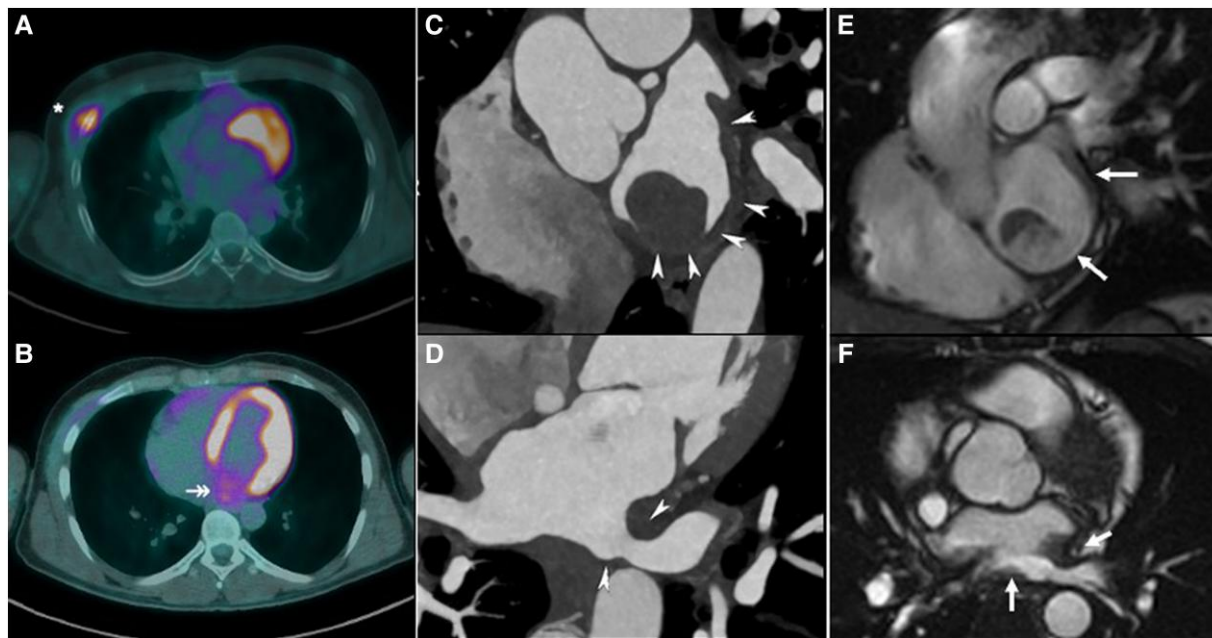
Multi-modality imaging of left atrial mass recurrence. A and B show hypercaptation in the myocardium, in the left atrial (B, double-pointed arrow) and also in the fifth left rib (A, asterisk) with soft tissue involvement (SUV_{max} of 5) in positron emission tomography/computed tomography-18F-fluoro-2-deoxy-D-glucose. C and D correspond to cardiac computed tomography images, revealing posterior left atrial wall and mitral leaflet invasion (C, arrowheads) and also contiguity to the pulmonary left veins' ostia (D, arrowheads). Cardiac magnetic resonance images are in accordance (E and F, respectively, arrows).
